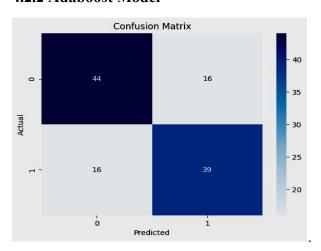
Confusion matrix for Adaboost. Positive CT findings as 1, Negative as 0.
